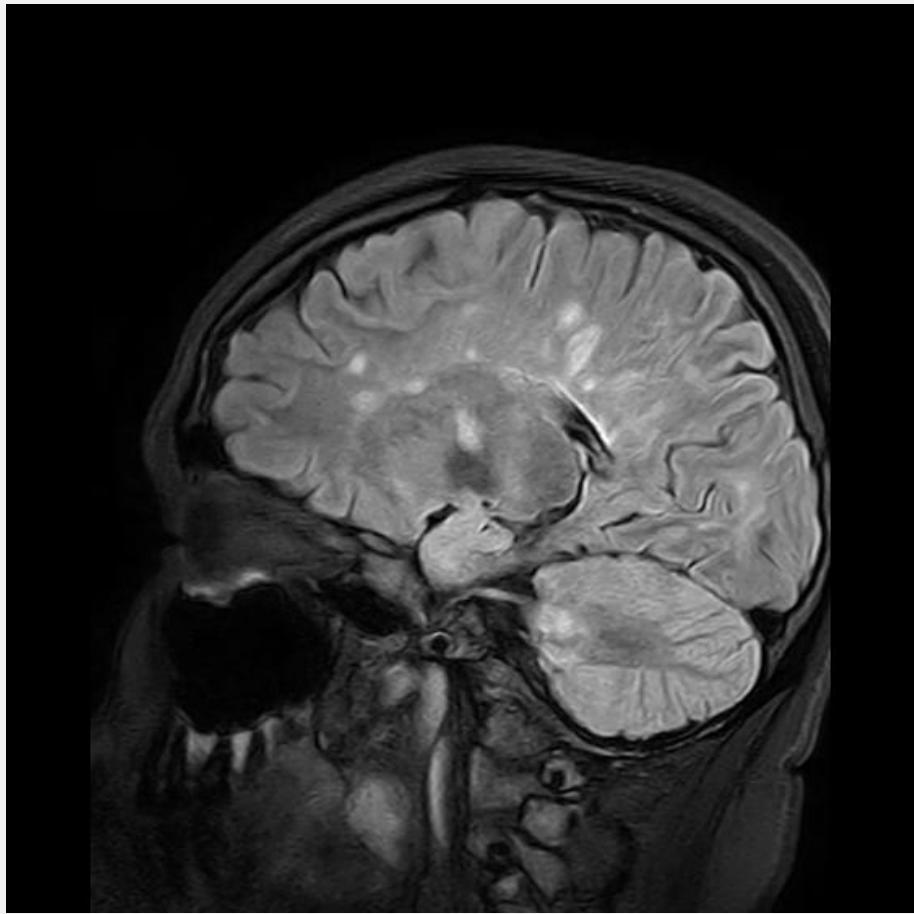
Patient with known MS with FLAIR hyperintense lesions (left), one of which enhances (right). MS plaques tend to be peri-venular and radial in distribution with common involvement of the corpus callosum.
